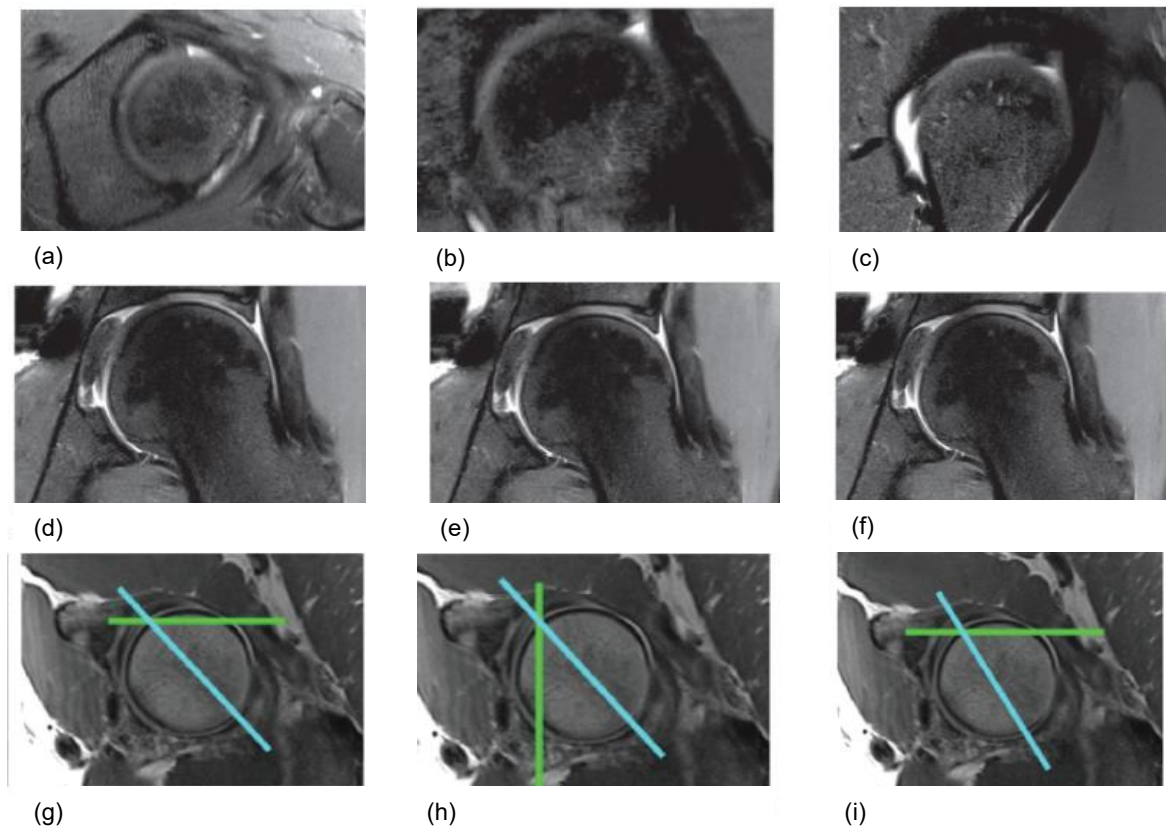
Comparison of conventional slices (a – axial oblique; b – coronal; c – sagittal) and radial (d-f) imaging planes. The MR images obtained at the level of the acetabular opening (g-i) show the location of conventional slices (green line) and radial slices (blue line). (Image from [28])
